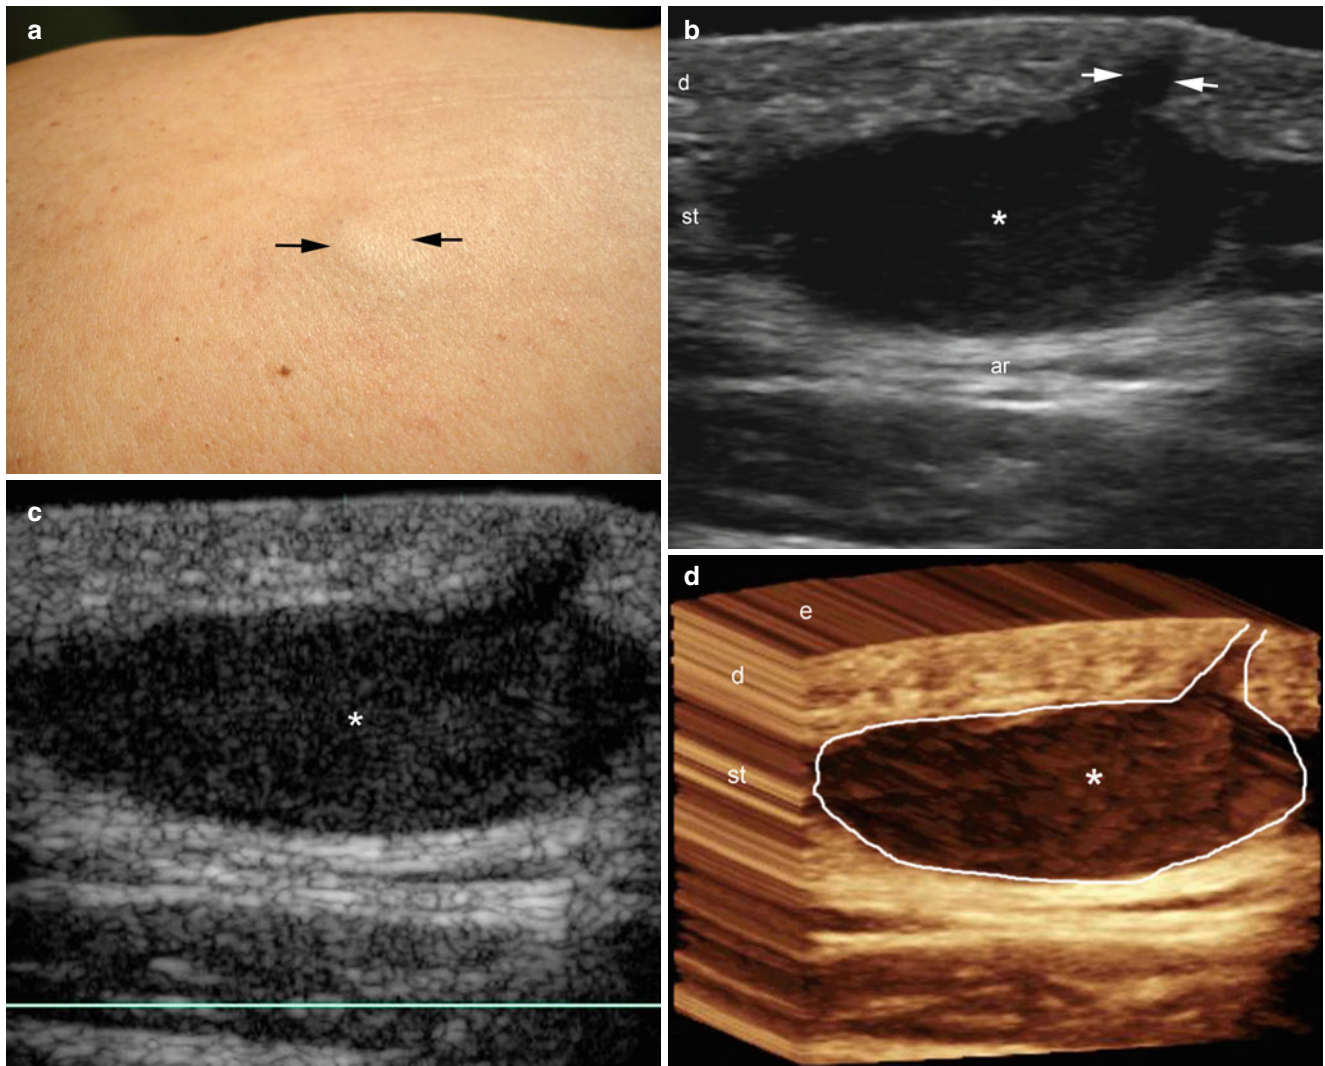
(a–d) Intact epidermal cyst. (a) Clinical lesion shows a skin colored swelling (*arrows*) in the left dorsal region. (b) Grey scale ultrasound image (transverse view) demonstrates a well-defined, oval-shaped anechoic structure (*) located in the dermis and subcutaneous tissue. Notice the communicating tract, also called punctum (*arrows*) to
